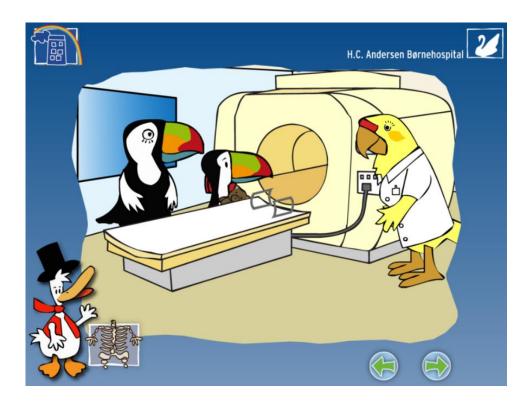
Animated scene in the app used for the preparation of children referred for MRI.
